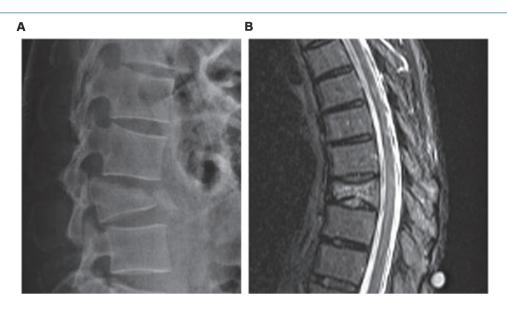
Imaging manifestations of OVCF. Note: A) X-ray film, B) MRI film.
